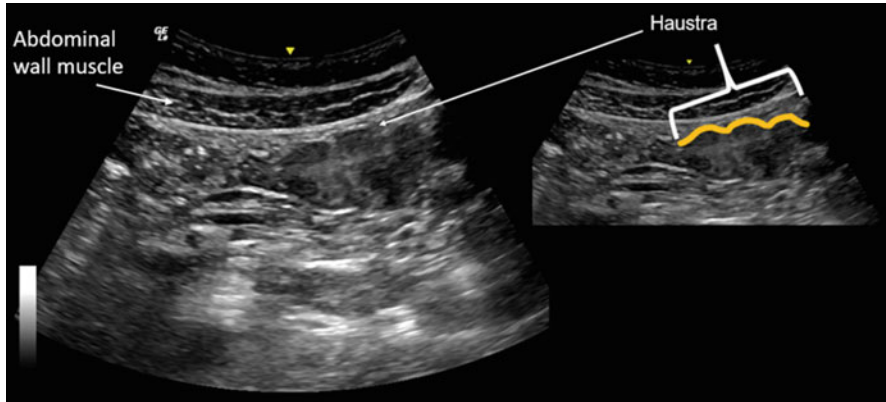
This is an ultrasound image depicting the large intestine (colon). Pouchlike haustra are created by contraction of the teniae coli muscles of the large intestine and can be used to differentiate large intestine from small intestine. In this image haustra are seen
